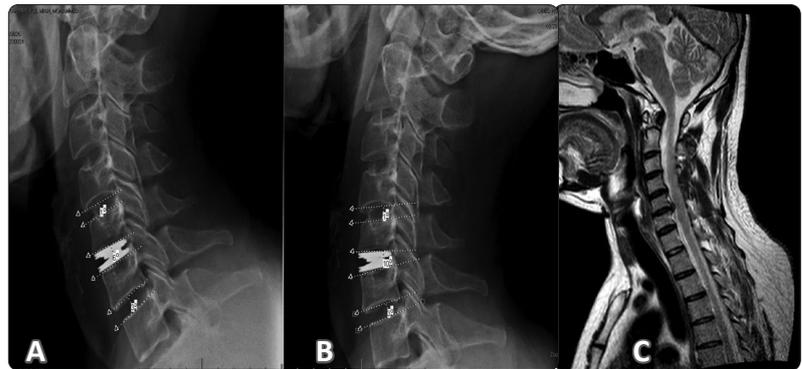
An 38 years old male, operated for cervical arthroplasty, (A) Preoperative MRI showing cervical disc C5-C6, (B, C) flexion extension study demonstrating shell angles at the operated level and the levels superior and inferior to it
